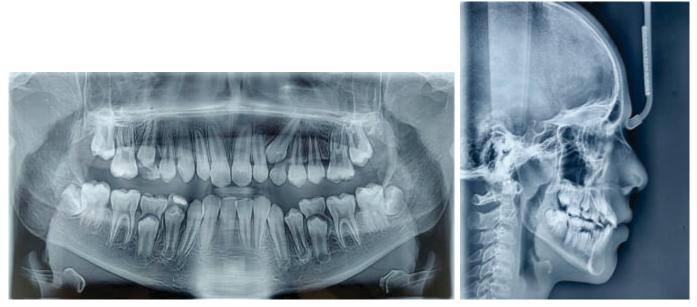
(8.1) Post-treatment lateral cephalometric radiograph. 8.2) Post-treatment orthopantomograph radiograph.
